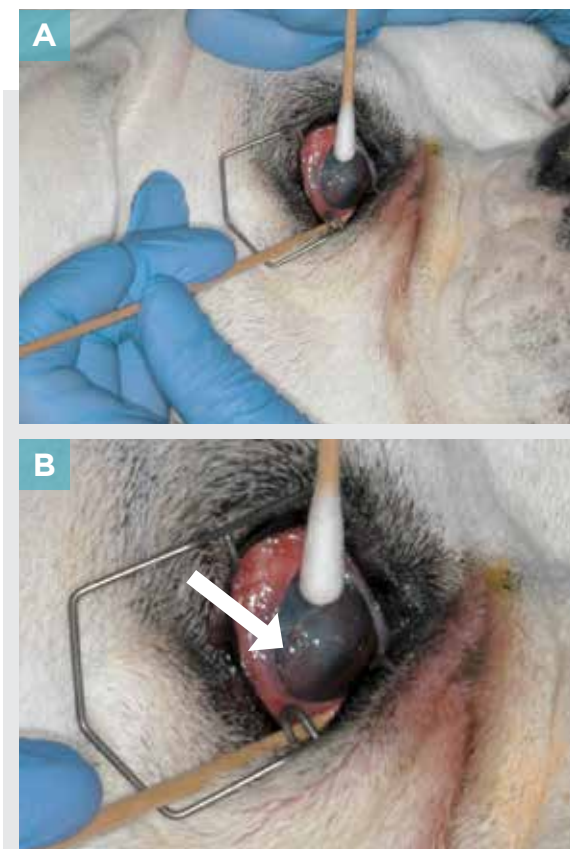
The first step of any surgical treatment is to debride any loose epithelia with a sterile cotton-tipped applicator (CTA). (A) A sterile eyelid speculum is being used to retract the eyelids, and a second sterile CTA is being used in the clinician's nondominant hand to retract the third eyelid. (B) Note the thin demarcation of loose epithelia between the lesion and normal cornea (white arrow).
